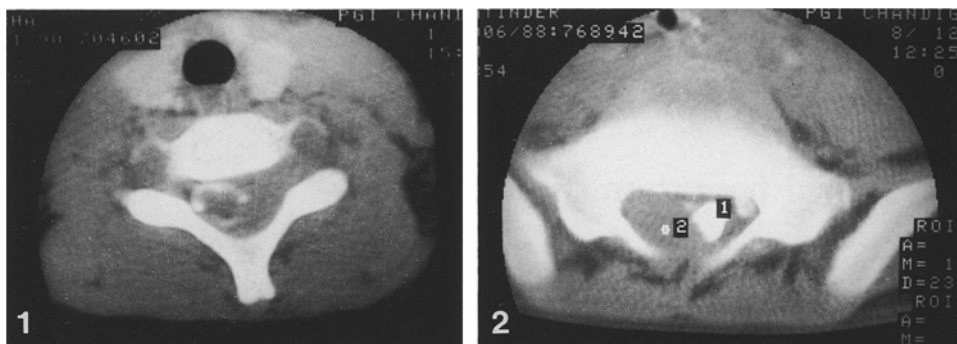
Iohexol computed tomography (CT) of cervical region showing extradural block from C5 to C7
